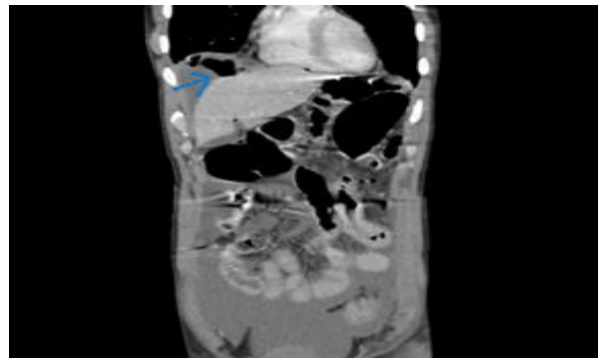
Coronal Section Of CT Scan Showing Hemopneumoperitoneum With Dilated Small Bowel
